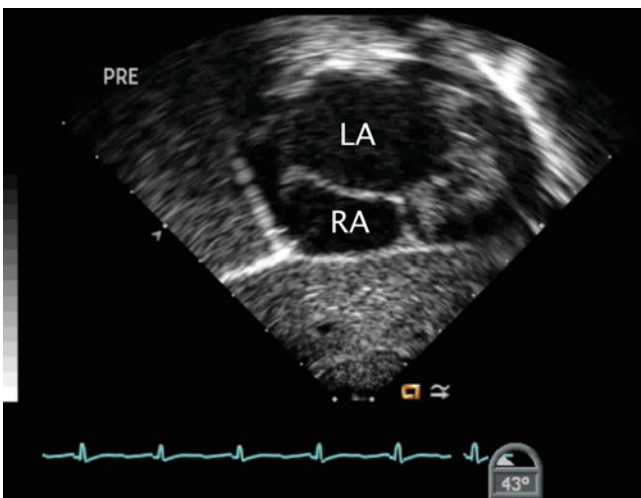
The image displays a modified plane in the deep transgastric window that also allows for echocardiographic assessment of the interatrial septum. *LA* left atrium, *RA* right atrium
